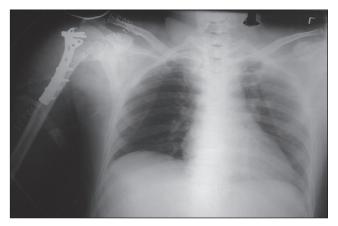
Postprocedure chest X-ray
